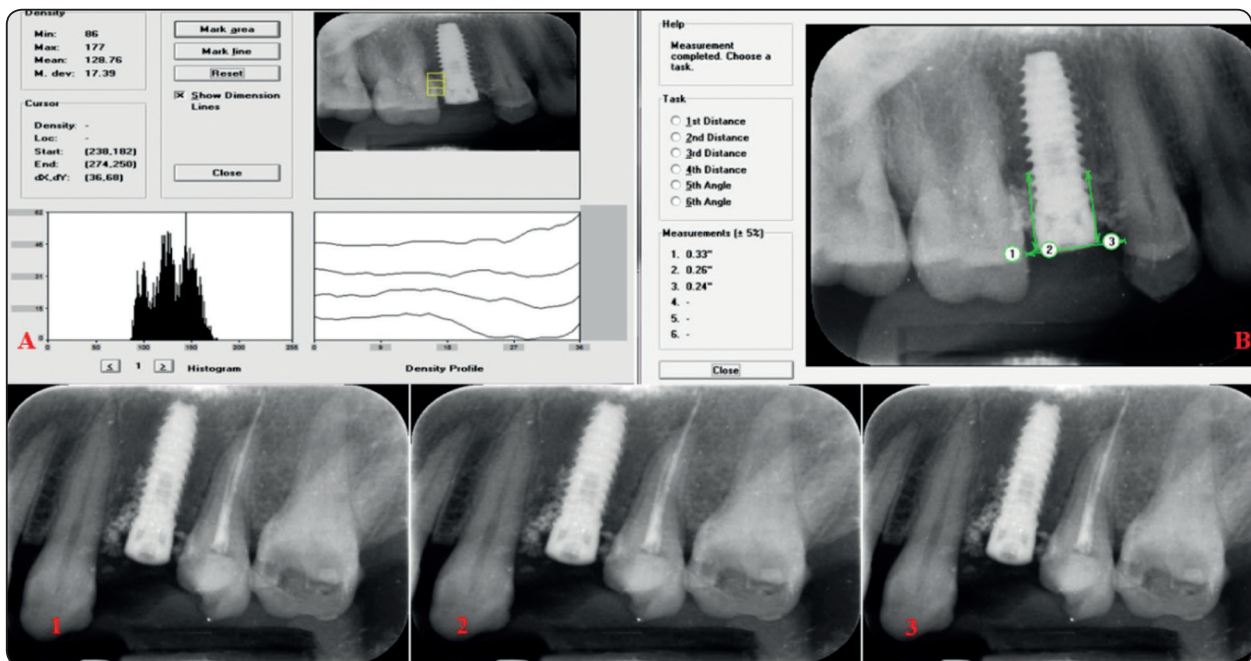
A. Digora software using the area density measurements method. B. Marginal bone height analysis by the Digora software. Periapical x-ray showing 1.Immediate postoperative radiograph. 2.Three months postoperative radiograph. 3.Six months postoperative radiograph.
